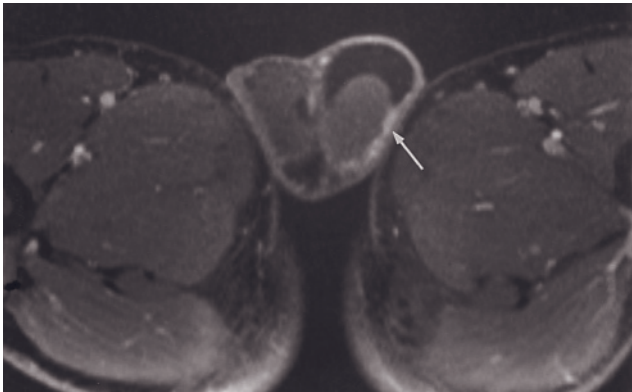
Hydrocele. Transverse T1-weighted gradient echo (a) and transverse 1-min postgadolinium T1-weighted fat-suppressed gradient-echo (b) images. A left-sided hydrocele is low in signal intensity on the T1-weighted image (a). A focus of high signal intensity within the fluid represents the spermatic cord (arrow, a). There is uniform enhancement of the testes on the postgadolinium image (b). Coronal SS-ETSE (c) and gradient-echo fat-suppressed postgadolinium (d) images in a second patient, a neonate, demonstrate a large left hydrocele. The testicle is low signal on T2 (c) but enhances moderately intensely on the postgadolinium image (d). Surface coil T2-weighted echo-train spin-echo image (e) in a third patient demonstrates a moderate-sized hydrocele.
